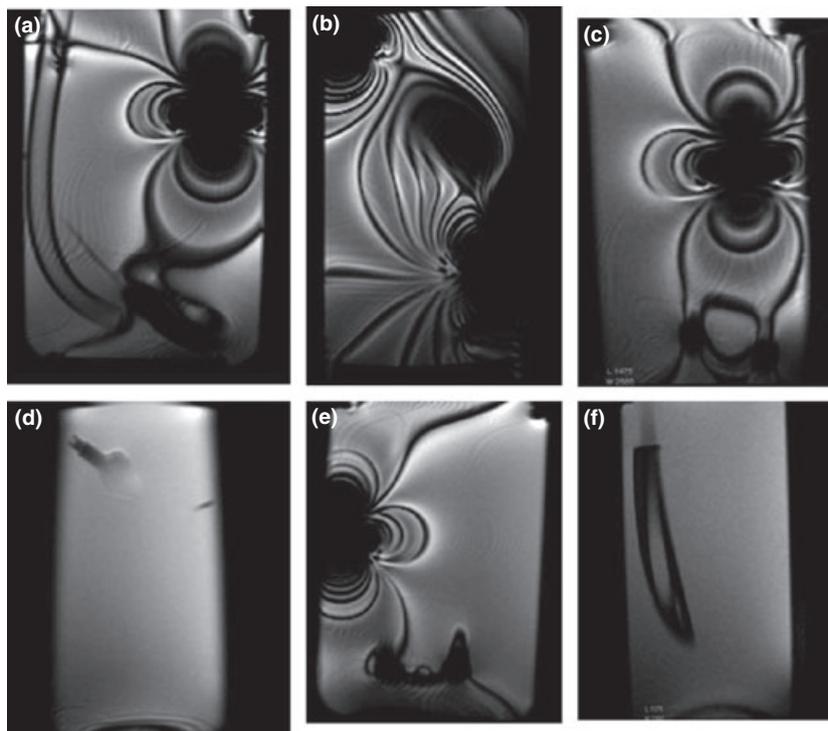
Sagittal magnetic resonance image showing the artefacts produced by the spring contained in the pilot balloon in (a), (c) and (e) (corresponding to the Classic LMA, LMA Unique, and LMA Supreme). In (b) (LMA ProSeal) the artefact is larger, produced by the summation of the metal in the pilot balloon and in the airway tube. In (d) (Ambu Disposable Laryngeal Mask) and (f) (i-gel supraglottic airway) there were no artefacts.
